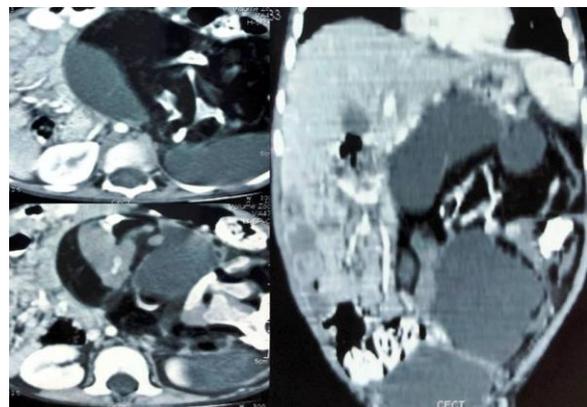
Axial and Coronal CT images in another pathologically proven case of Fetus in Fetu showing presence of large left retroperitoneal mass with presence of large cystic and fatty mass causing displacement of adjacent bowel loops. Multiple irregular vertebral bodies, rib like structures and long bones also seen in the mass.
